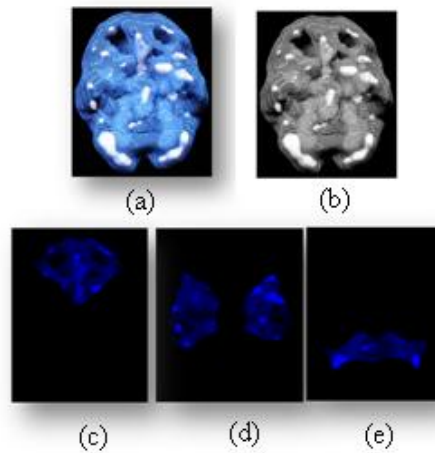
(a) SPECT Image (View Type: Active). (b)Grayscale Image. (c)Frontal lobe. (d)Temporal lobe. (e)Occipital lobe
